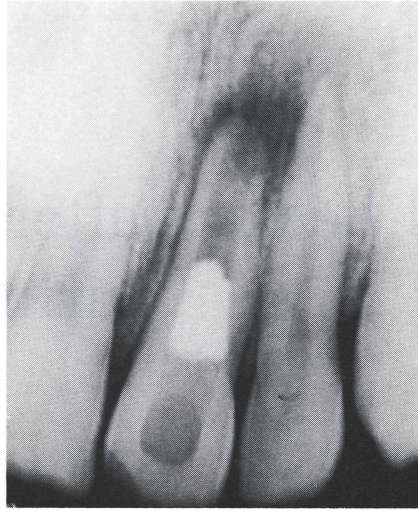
Radiograph of central incisor immediately after apicocurettage.
